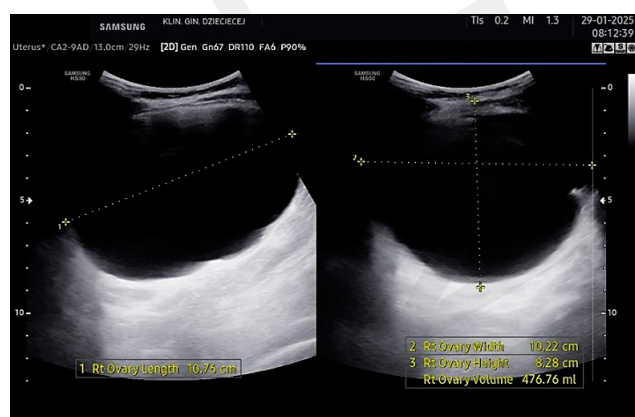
Ultrasonography (Case 3)
